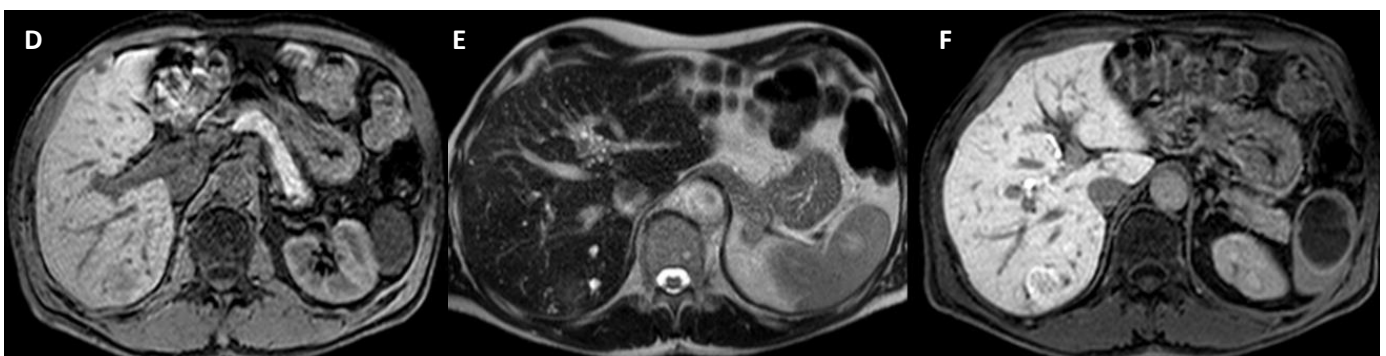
A – Ultrasound – steatosis, diffusely increased echogenicity of the liver compared to parenchyma of healthy kidney
